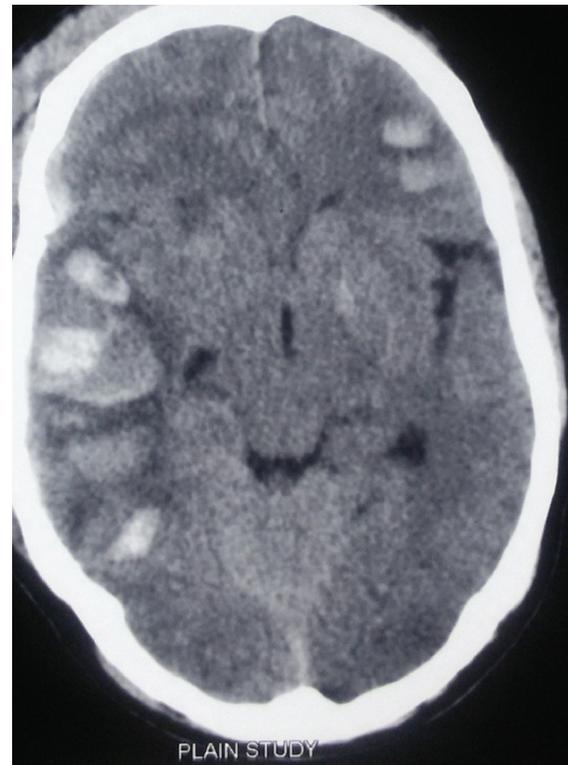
CT Brain showing hyperdense lesion in the right vein of Labbé territory with evidence of obliteration of ipsilateral ambient cistern.
